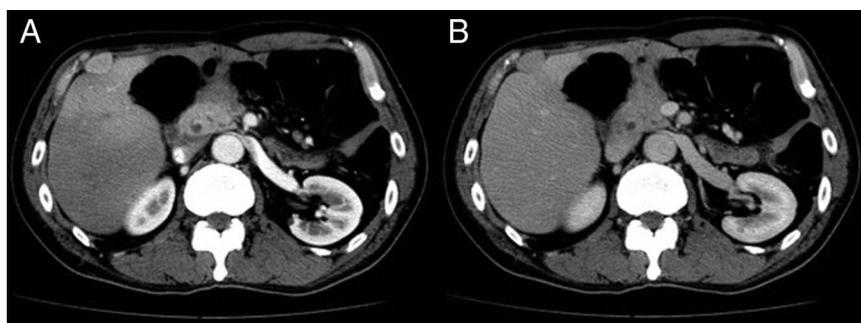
Contrast-enhanced computed tomography revealed a 24.6 × 16.9-mm tumor on the surface of liver segment 5 that was contrast-enhanced in (A) the early phase and the contrast was washed out in (B) the late phase.
